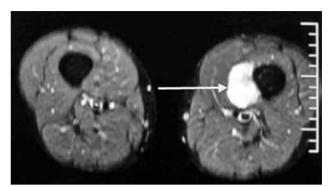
T₂ weighted magnetic resonance imaging of the tumoral mass (arrow).
